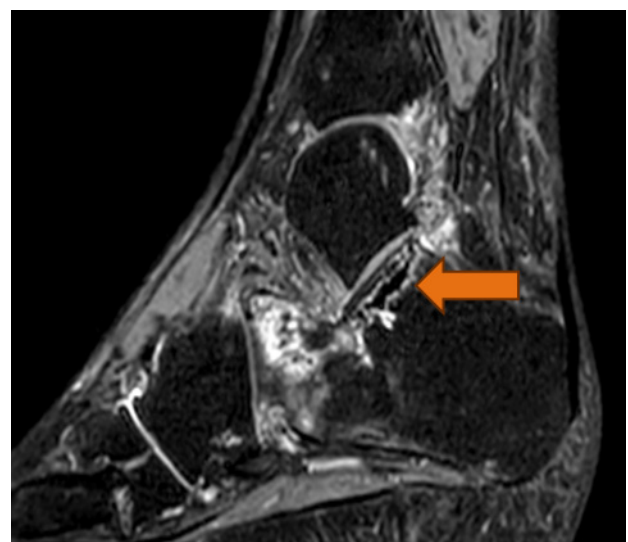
MRI of the right ankle, STIR sequence. Linear fracture of the calcaneus beneath the posterior facet.
